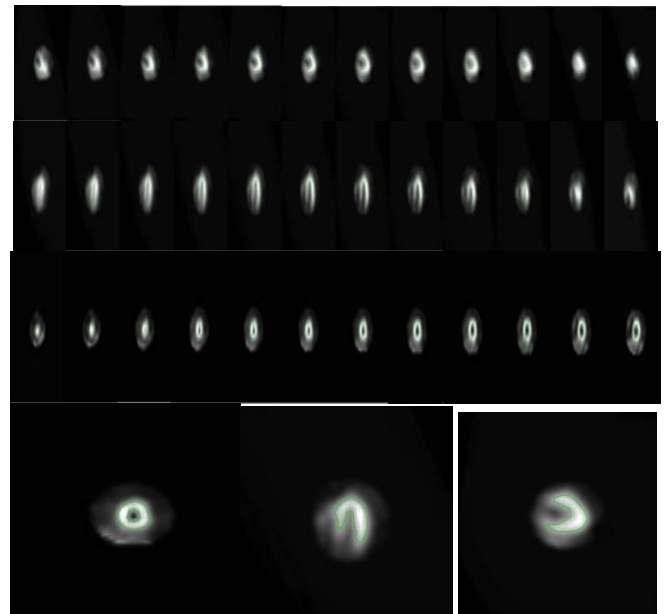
Segmented SPECT image obtained using registration techniques
